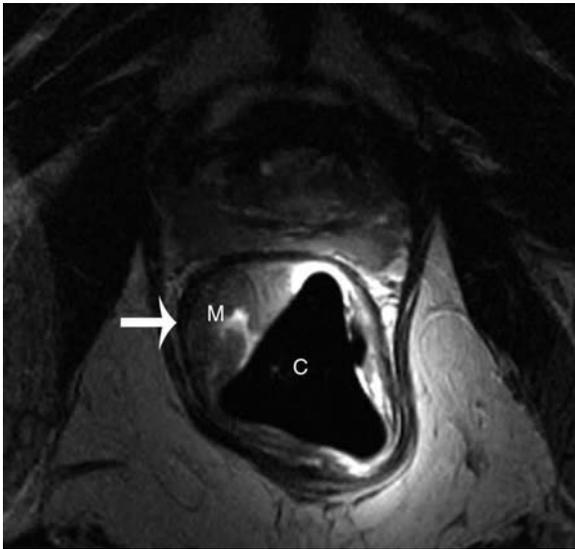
Stage T1 rectal carcinoma in a 65-year-old female. Axial T2-weighted image with an endorectal coil (C) reveals an intermediate T2 signal intensity mass (M) corresponding to the patient's biopsy-proven rectal carcinoma confined to the rectal mucosa. The lower T2 signal intensity rectal wall (arrow) is intact. (Please note: that while this is a beautiful image, we no longer routinely use endorectal coils for rectal cancer staging.)
